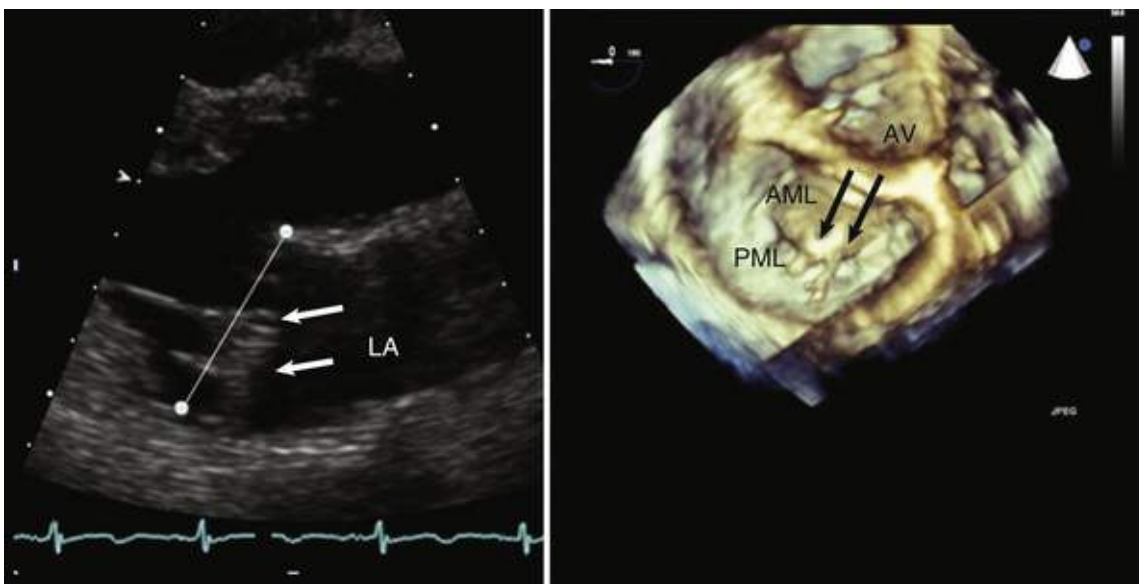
Degenerative MR. Left, Parasternal long-axis view showing bileaflet prolapse, as evidenced by billowing of both leaflets (*arrows*) above the annular plane, defined by the insertion of the anterior and posterior leaflets (*line*). Right, 3D TEE image of the mitral valve from the left atrial perspective. There is a large flail segment of the anterior mitral leaflet (*AML*). *Arrows* point to ruptured chordae. AV, Aortic valve; LA, left atrium; PML, posterior mitral leaflet.
